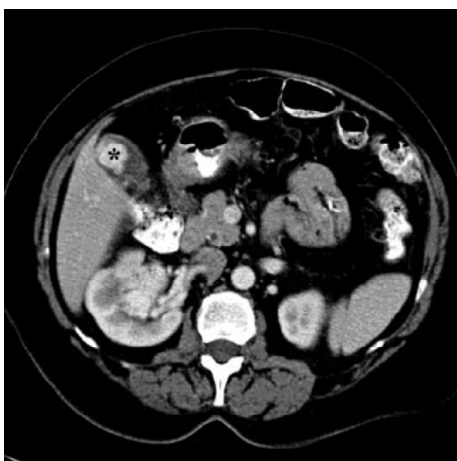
CT of primary RCC with gallbladder metastasis. There is a right renal tumor and associated mass in the gallbladder (black asterisk). Both lesions demonstrate similar hypervascular enhancement.
